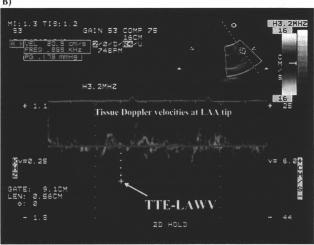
(A) TTE-LAWV was measured by DTI at the LAA tip from the parasternal short-axis view in diastole. (B) Tissue Doppler velocities were obtained, and the peak wall velocity of downward atrial waveform within each RR interval was averaged. AoV, Aortic valve.
